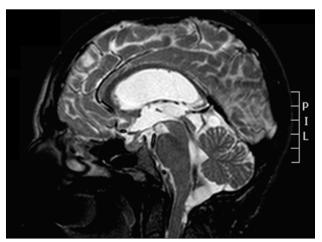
Preoperative sagittal T2-weighted magnetic resonance imaging (MRI) showing several cysts in cerebellomedullary cisterna obstructing cerebrospinal fluid flow, and showing hydrocephalus.
